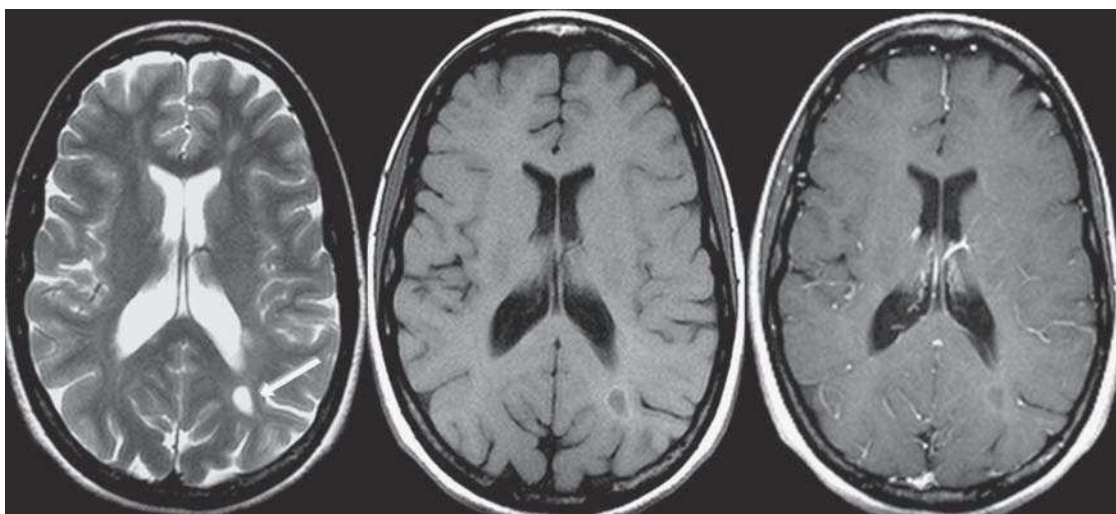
Brain magnetic resonance imaging. T2-weighted sequences (left), T1 (middle) and contrast T1 (right) in the transverse plane in a patient with secondary progressive multiple sclerosis. Note the posterior subcortical demyelinating lesion in the left cerebral hemisphere (arrow), which shows a hyperintense ring in the post-contrast T1 sequence. This lesion is not enhanced by contrast.
